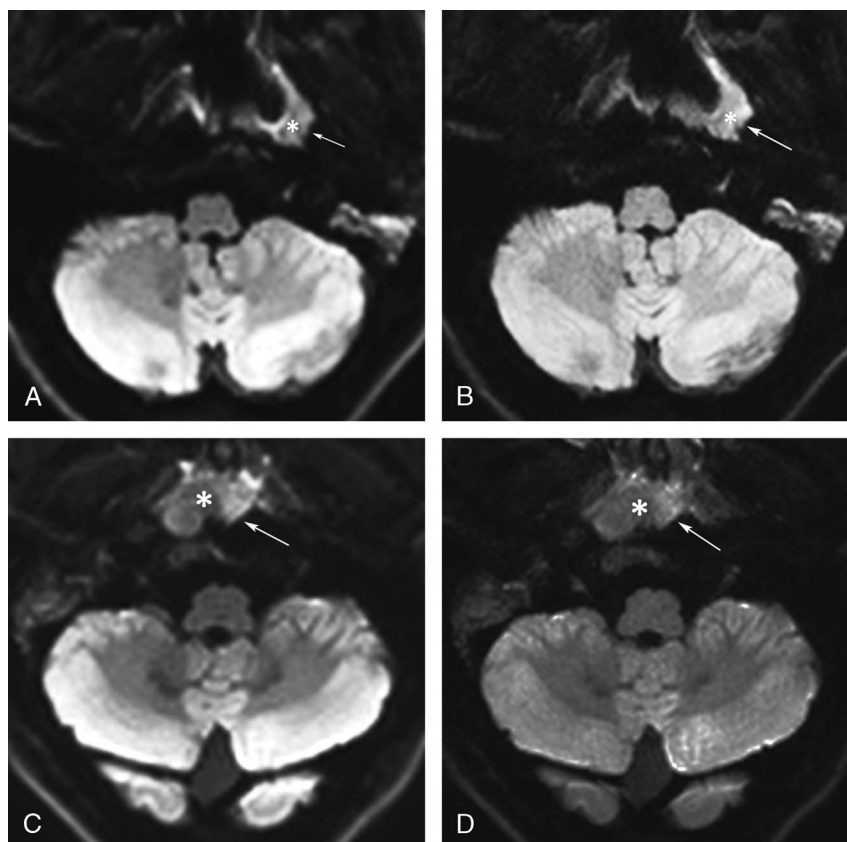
Nasopharyngeal carcinoma in a 67-year-old patient and a 53-year-old patient, respectively. Both b800 maps displayed the mass (white star) with restricted diffusion well, whereas compared with RS-DWI (A, C), SMS-RS-DWI (B, D) showed less susceptibility artifacts (white arrow), improved image quality, and more clearly tumor edge.
